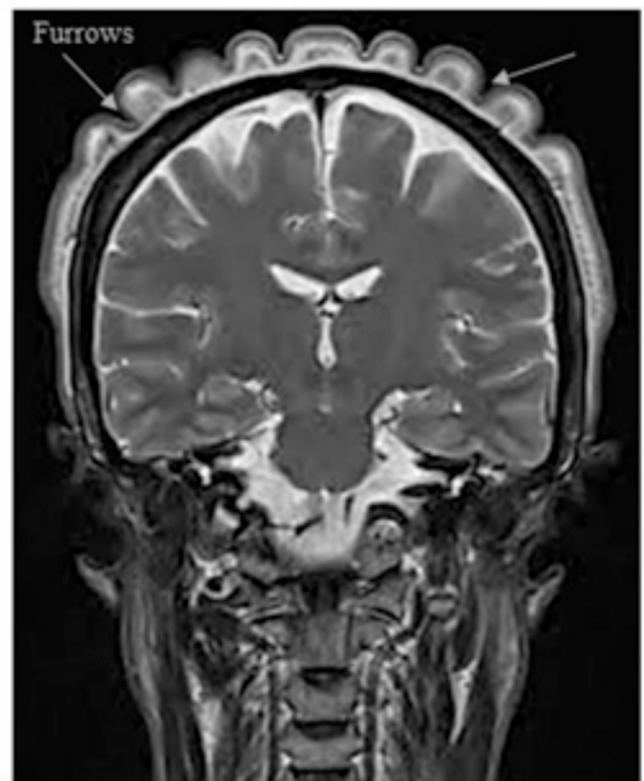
Showing MRI report of the patient with development of deep cutaneous furrows.
